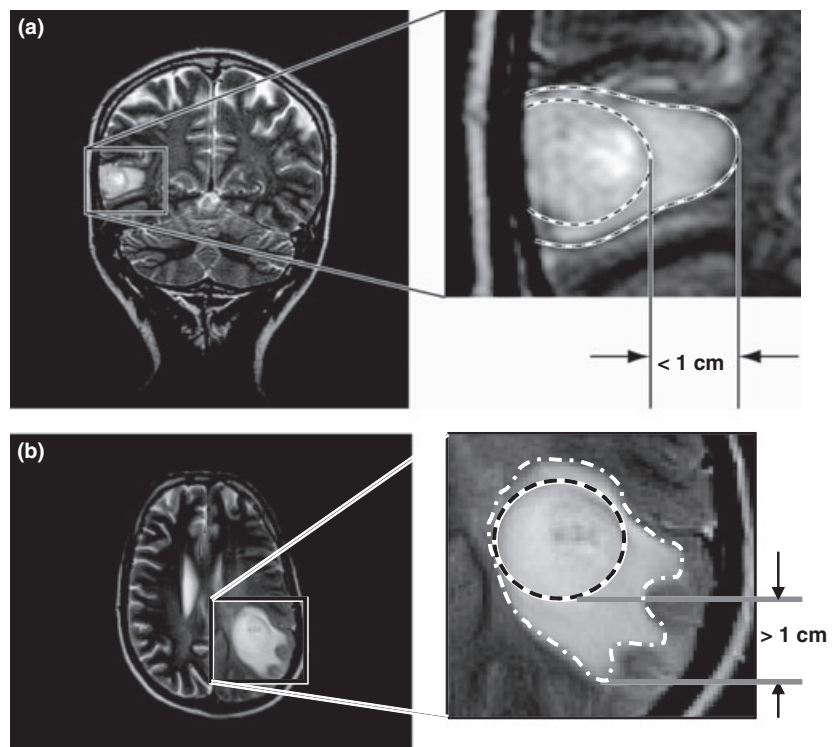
Measurement of peritumoral edema by means of MRI T2 (coronal/axial) weighted images. (a) Coronal T2-weighted images showing peritumoral edema extending less than 1 cm from the tumor margin, which was defined as minor edema. (b) Axial T2-weighted images showing peritumoral edema extending more than 1 cm from the tumor margin as major, which was defined as major edema.
